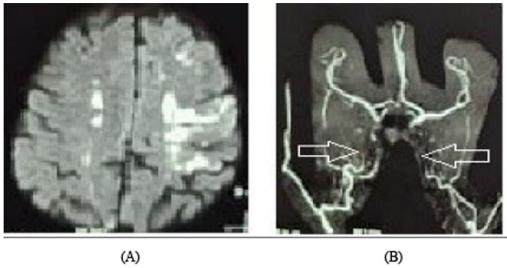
MRI and MRA show bilateral parietal lobe infarctions in the distribution of the MCA. Diffusion_weighted axial image: A of the brain MRI showed acute infarcts in both parietal lobes, B MRA showed vasospasm of the right internal carotid artery and complete occlusion of the left internal carotid artery
